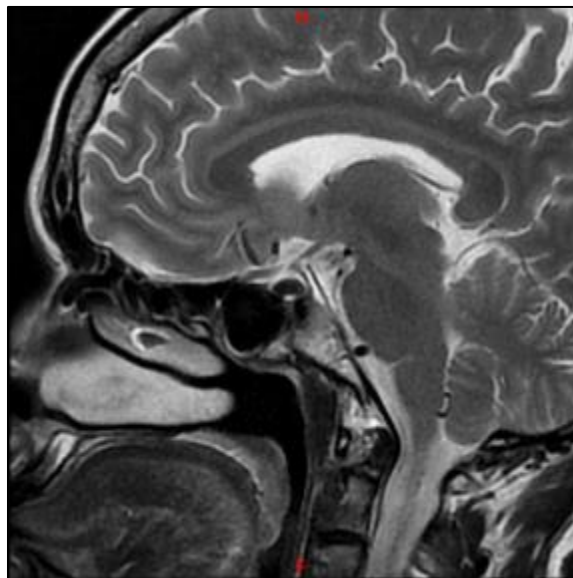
Magnetic resonance imaging of the case showing empty sella appearance
